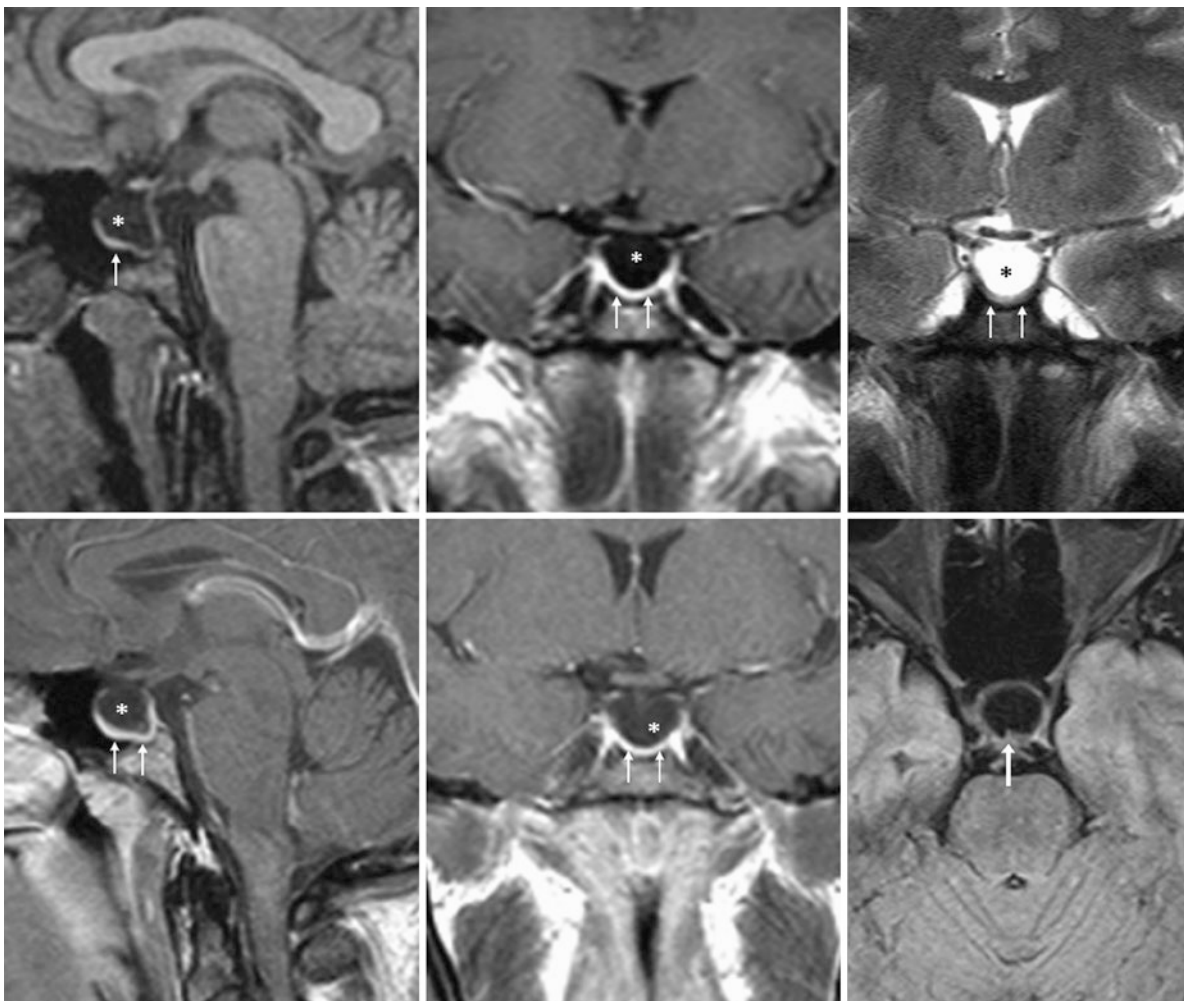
A 40-year-old female patient had headaches and a partial PES (*) on an otherwise negative 1.5 T MRI; the stalk was not seen at that time. Note a thin rim of tissue (thin arrows) on sagittal noncontrast (top left) and coronal postcontrast (top middle) T1WIs and on coronal
